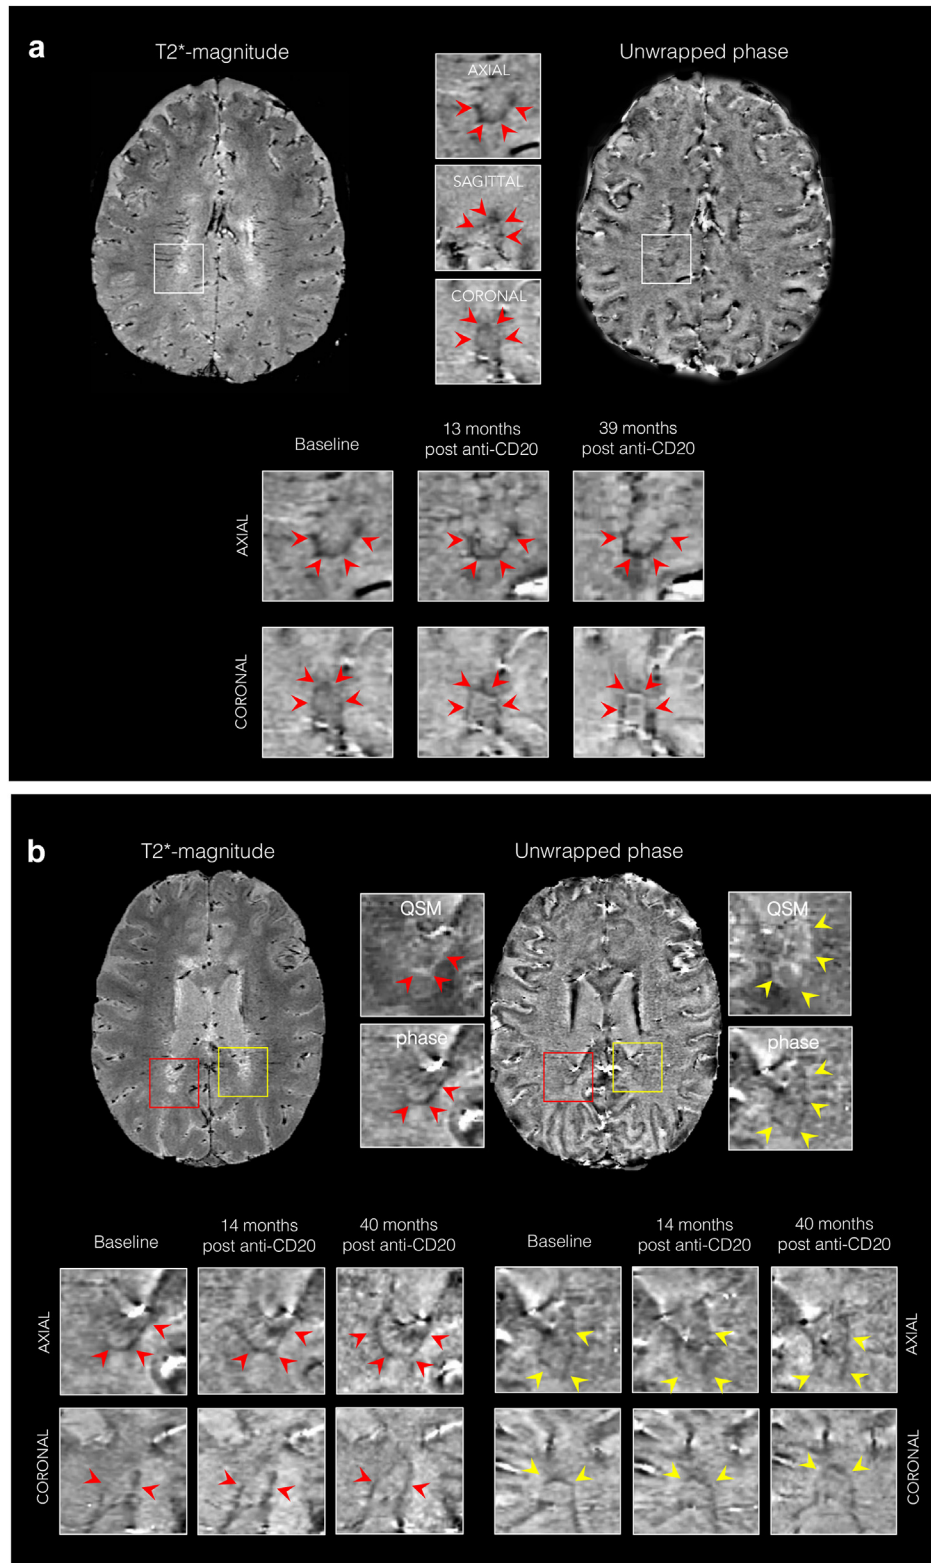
Lack of evolution of paramagnetic rim lesions after anti-CD20 treatment. Representative 3D T2*-weighted magnitude and unwrapped phase MRI images showing paramagnetic rim lesions (PRL) with persistent paramagnetic rims in (a) a 31-year-old with PPMS
